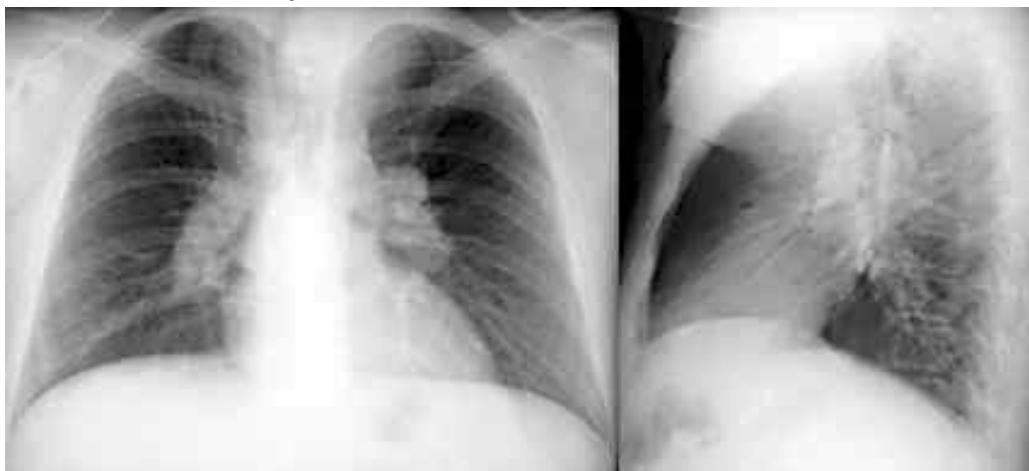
Radiograph: Bilateral perihilar lymphadenopathy.
